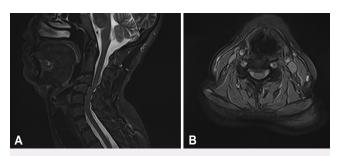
A: Preoperative sagittal T2-weighted MR image of the cervical spine, showing marked cervical lordosis with visible degenerative changes of the definitive spondylosis type and discrete spondylarthrosis on the right side. Degenerative retrolisthesis of the vertebral bodies at the level of C3–4 and C4–5 was more pronounced in the proximal part. B: Axial T2-weighted MR image of the C4–5 level, showing disc herniation at the C4–5 level accompanied by patient-demonstrated clinical signs consistent with myelopathy, as evidenced by a significant reduction in spinal canal diameter measuring up to 7.4 mm.
